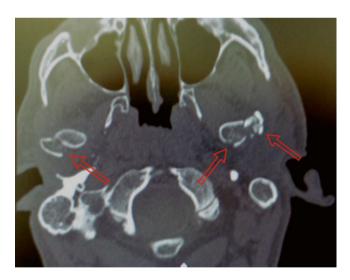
CT evaluation of condylar fractures can be very useful. Comminution (which may not necessarily be seen on plain films) may contraindicate repair
